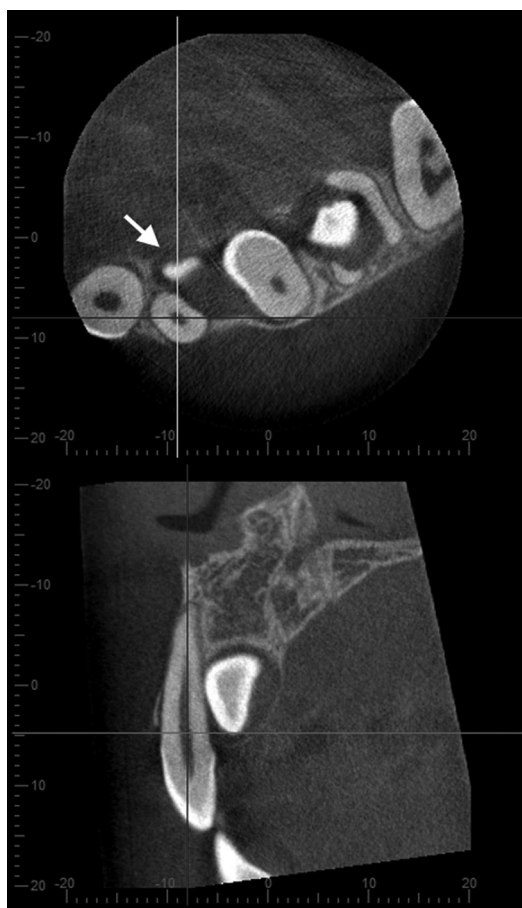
Vertical location of the cusp tip (arrow) in relation to the long axis of the neighbouring lateral incisor on sagittal and axial CBCT scans, representative example.
